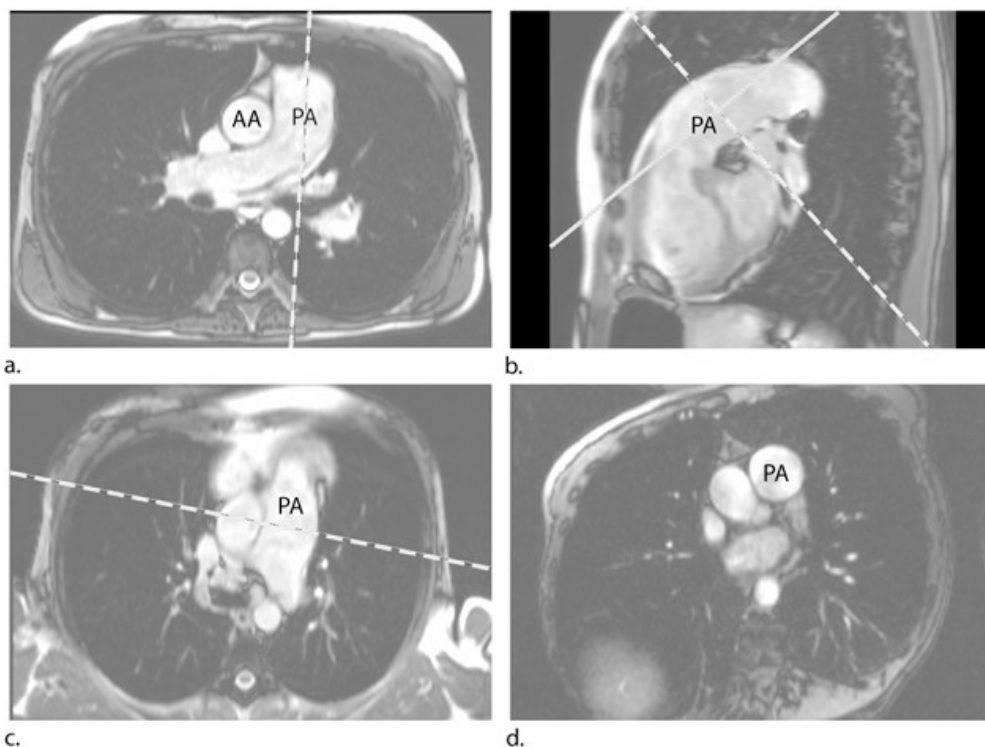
(a), (b) and (c) are steady-state free precession MR images to localize the pulmonary trunk (repetition time msec/echo time msec, 3.2/1.6; flip angle, 65°; section thickness, 6 mm; matrix, 256 × 96). First, an image was prescribed perpendicular to a transversal view (a) that included the pulmonary artery. This resulted in an oblique-sagittal image as shown in (b). A third localizer image shown in (c) was acquired according to the straight line in (b), and used together with (b) to obtain the image plane for the through-plane velocity measurement in the main pulmonary artery (PA). Image (d) shows the cross section of the main PA, acquired as the magnitude image in the flow measurement. This acquisition was with a gradient-echo sequence with through-plane phase-contrast velocity quantification (see text for details). In addition (a) shows also the plane orthogonal to the ascending aorta, in which the aortic diameter is measured that is used for normalization of the PA size with respect to the aorta. PA: Pulmonary Artery, AA: Ascending Aorta
